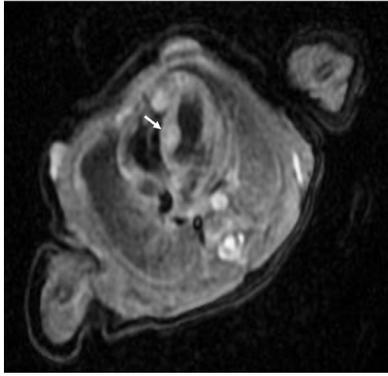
A 43-day-old male patient. Cardiac MRI T1 double-IR sequence in 4-chamber view shows an intraventricular septum cardiac rhabdomyoma (white arrow).
